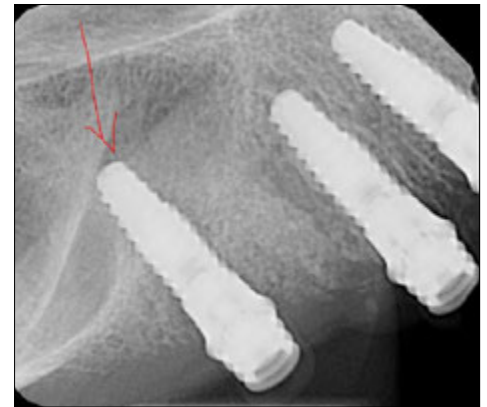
Periapical radiograph showing the failed implant.
